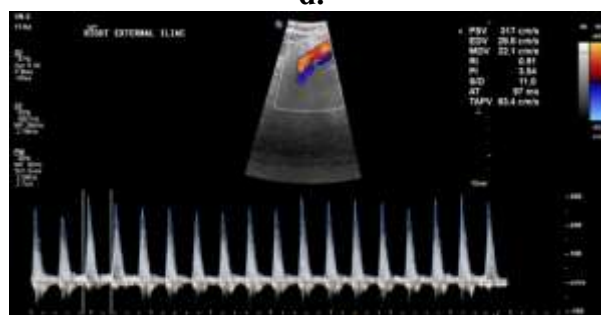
Image- d. Color doppler and Spectral waveform image at right external iliac artery showing Anterograde, High velocity, Monophasic waveforms.
